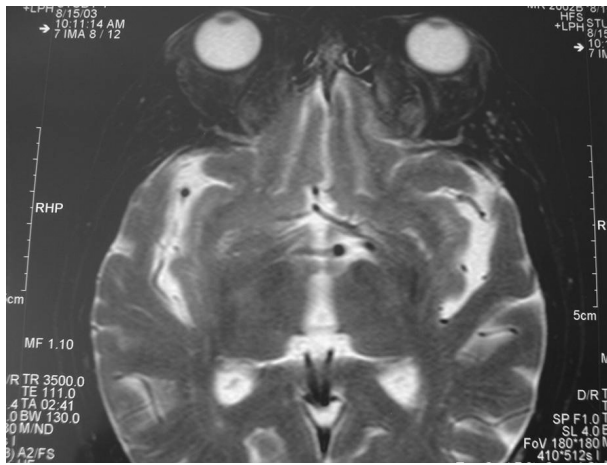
A: Cranial MRI and angiography examinations detecting fistula
